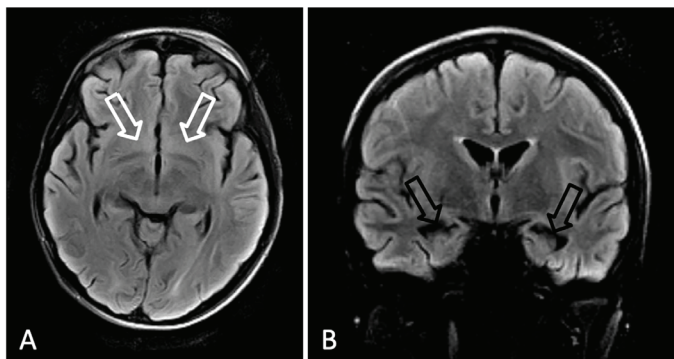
(A) Axial T2-FLAIR shows normalized signal in the globus pallidus (empty white arrows). (B) Coronal T2-FLAIR shows ventricular enlargement consistent with bilateral hippocampal atrophy (empty black arrows). T2-FLAIR: T2-fluid-attenuated inversion recovery
